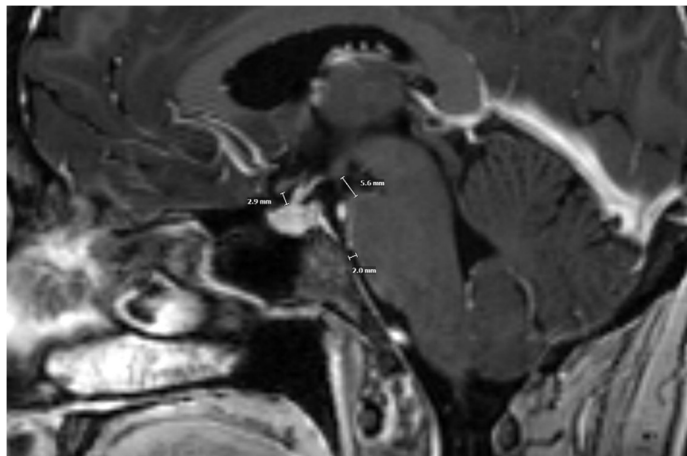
Midline sagittal T1 post-gadolinium MPRAGE MR image from a patient without SIH demonstrates an intermediate probability Bern score of 4 due to decreased mamillopontine distance, prepontine cistern effacement, and suprasellar cistern effacement.
